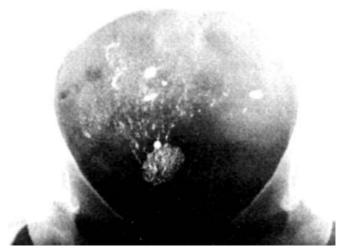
Early diffuse calcification in a large leiomyoma, the mineral 'streaming' along the lines of presumed vascular channels. (Radiograph presented by Mr CH Walsh)
